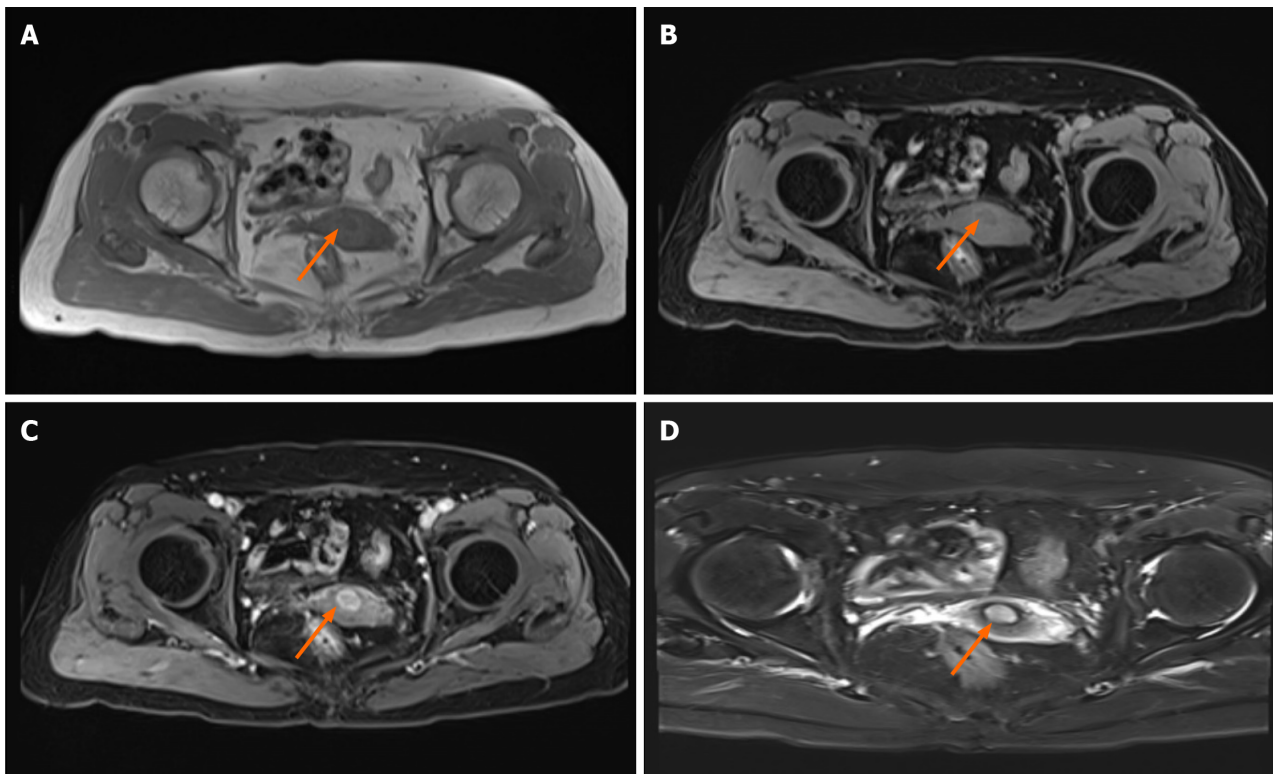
Pelvic magnetic resonance imaging. A: T1 weighted image (arrow); B: Fat-suppression T1-weighted image (arrow); C: T1WI lipocompression enhanced scan (arrow); D: T2WI lipocompression enhanced scan (arrow).
